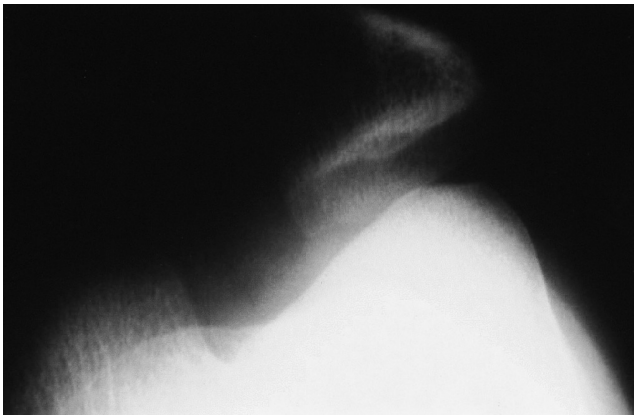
Simple radiography of right knee shows patellar hypoplasia.
